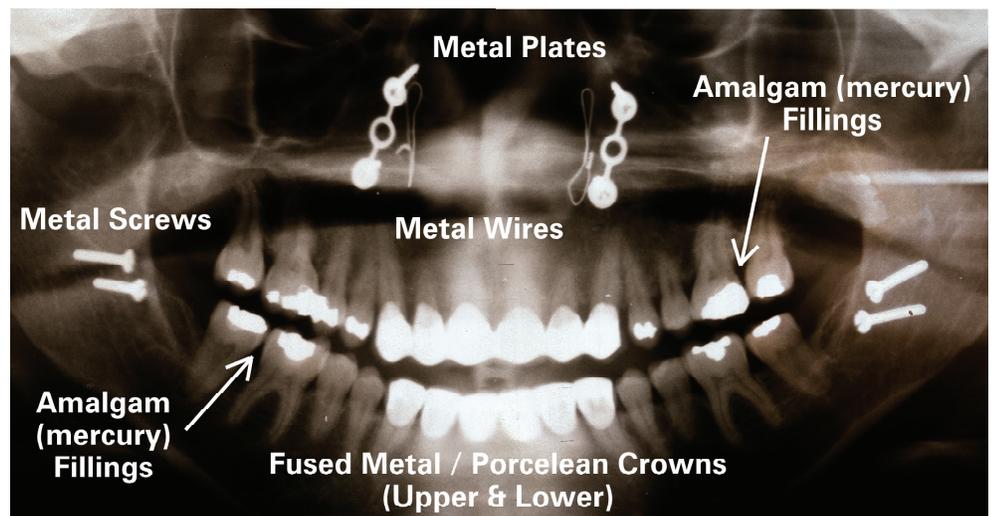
Panoramic X-ray showing various metals
